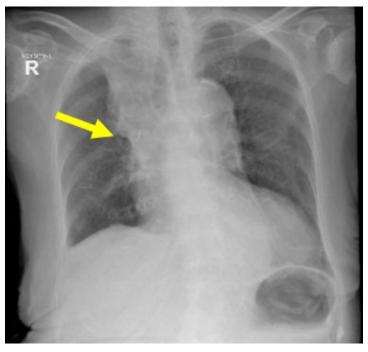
Repeat chest radiograph post-treatment, on follow-up, shows a significant decrease in the right pleural effusion with decreased haziness in the right upper lobe (pointed).
